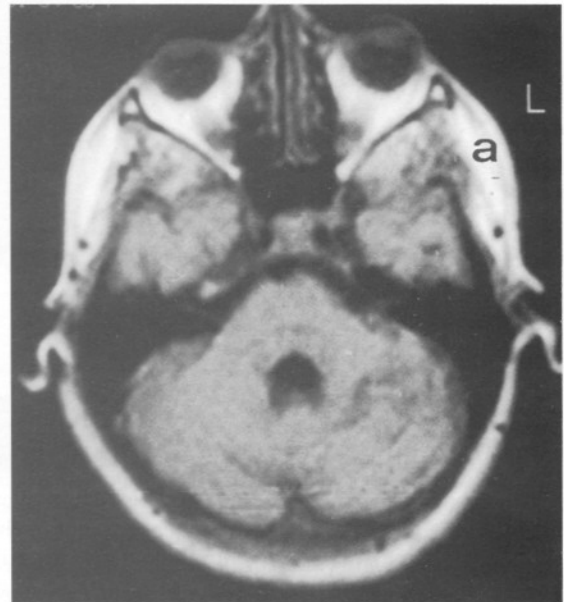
a and b. Control MRI demonstrates no signs of recurrence; hydrocephalus and syringomyelic cavity have disappeared.
